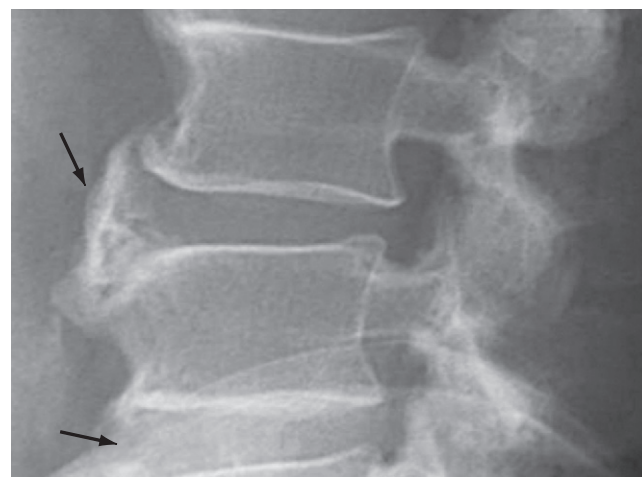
Diffuse idiopathic skeletal hyperostosis (DISH): lumbar spine. This lateral radiograph of the lumbar spine shows early changes of DISH. Calcifications of the anterior longitudinal spinal ligament (arrows) are evident and will eventually evolve into flowing osteophytes extending across multiple spinal levels.
